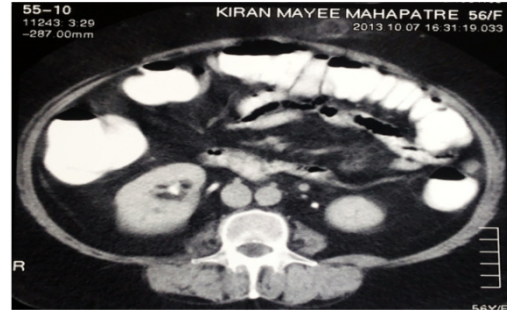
CT scan section showing abdominal wall metastasis along the lateral border of the rectus sheath on the left side
